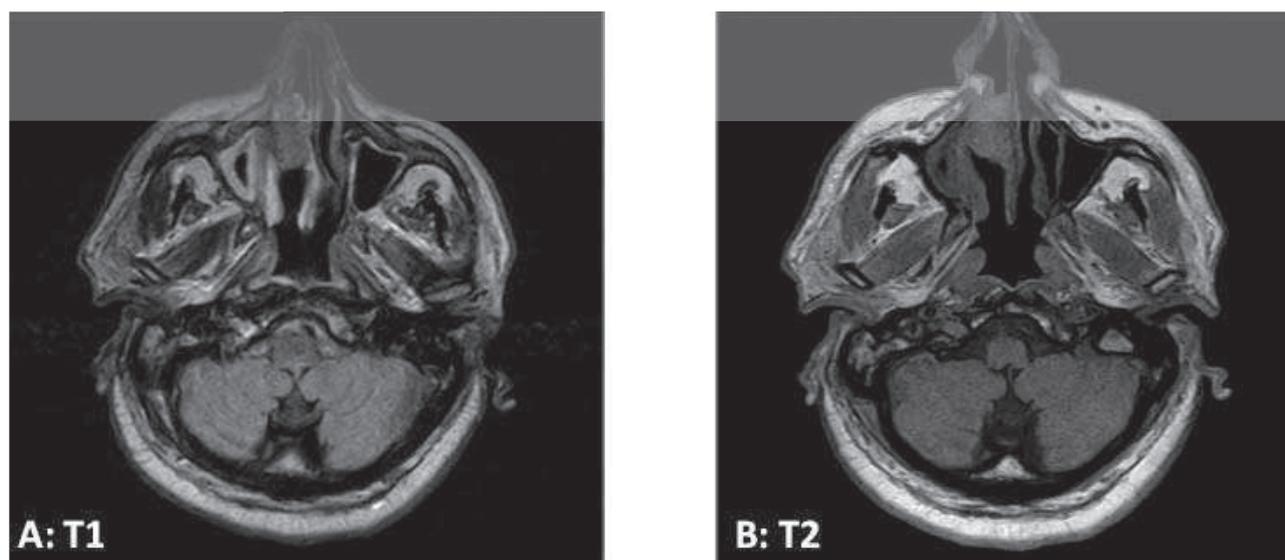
Magnetic resonance imaging (MRI) with contrast enhancement. MRI showed an ovoid formation of relatively hyperintense signal in T1 axial sequence (A) and of relatively hypointense signal in T2 axial sequence (B) in the right nasal cavity.
